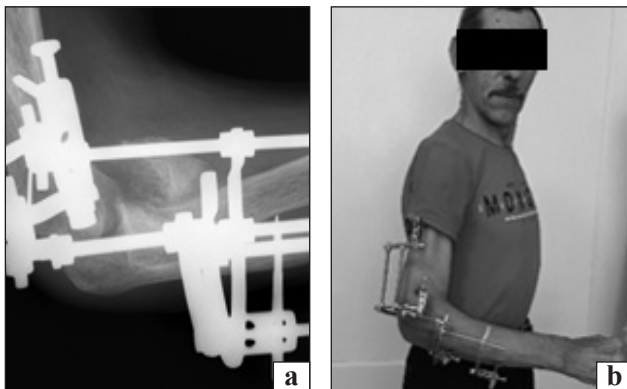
Radiograph of the elbow joint (a) and the appearance of patient S. (b) after the completion of the preparation procedure for the development of movements in the joint
